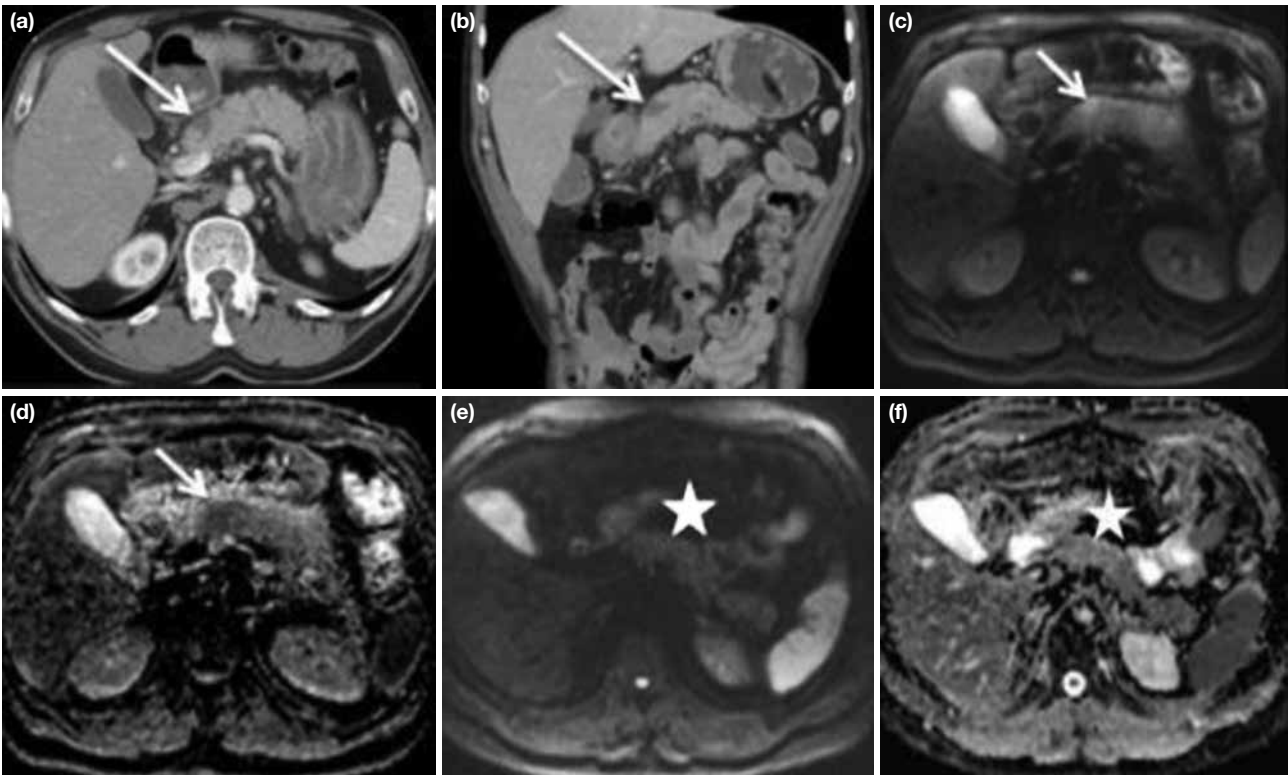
a–f. Focal pancreatitis in a 55-year-old man. Contrast enhanced CT shows a focal hypodense area (long arrow) at the body of pancreas compatible with focal pancreatitis (a, b). Axial diffusion weighted MR image ($b=1000$ sec/ mm^2) shows the focal pancreatitis (short arrow) as a hyperintense area with corresponding hypointensity on axial ADC map (restricted diffusion) (c, d). After medical treatment, follow-up diffusion weighted MR images show disappearance of diffuse enlargement of pancreas and focal pancreatitis (star) (e, f).
